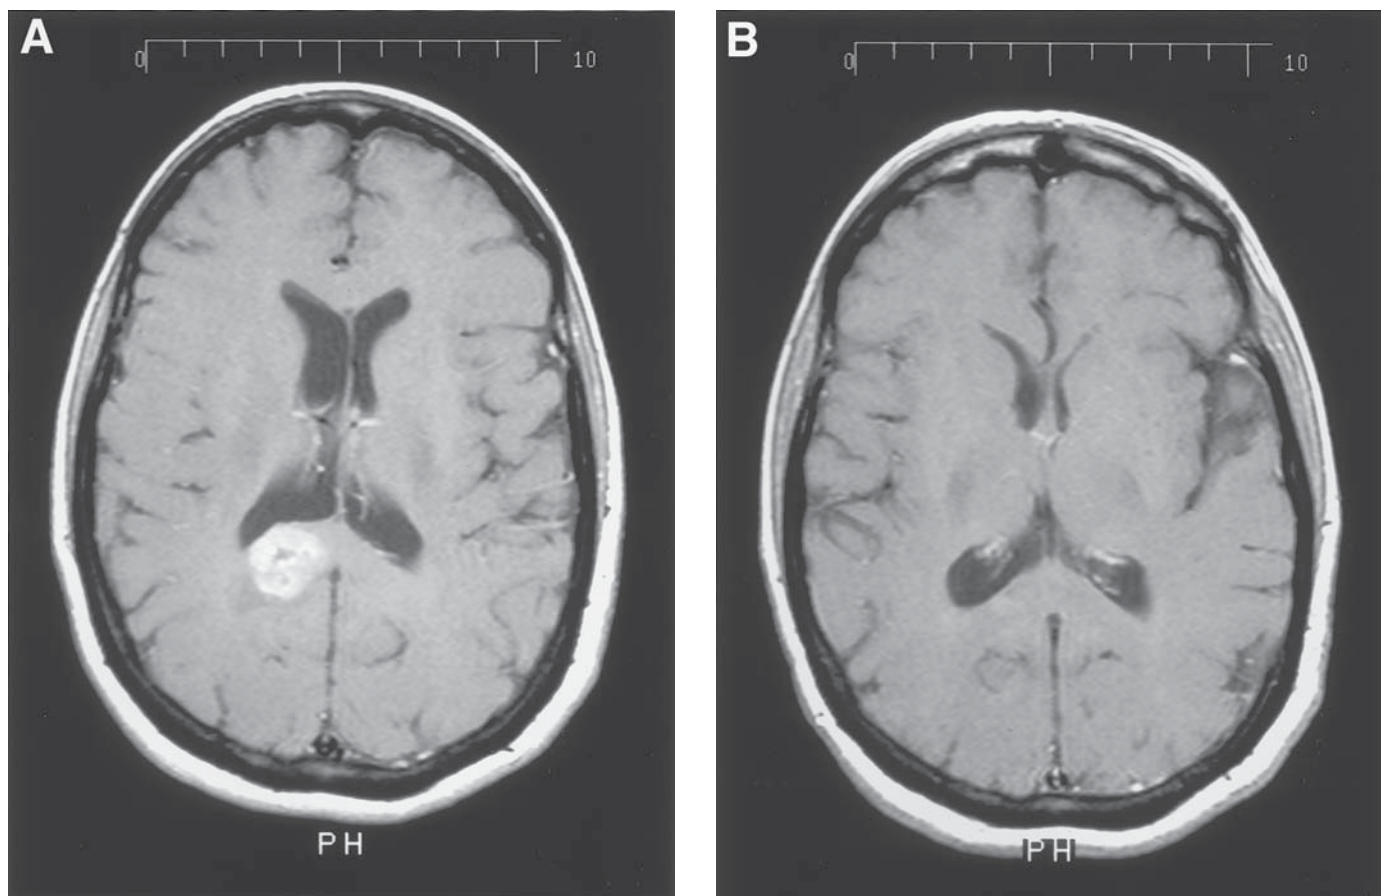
Gadolinium enhanced MRI scan of a 50-yr-old ovarian cancer patient with a brain metastasis treated with ifosfamide. (A) is pretreatment and (B) is after 4 cycles of chemotherapy. This patient was felt to be a poor candidate for radiotherapy as she also had a diagnosis of multiple sclerosis.
